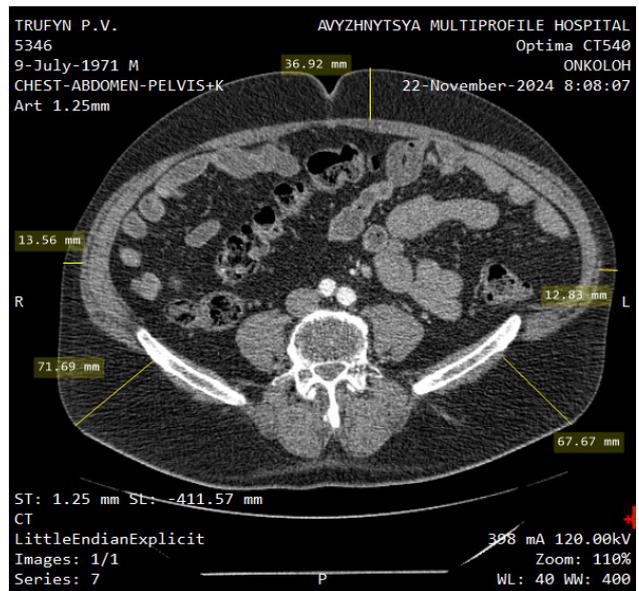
CT scan of patient T., 53 years old with grade I obesity, performed at the navel level. The thickness of the subcutaneous fat tissue ranges from 12.83 to 71.69 mm.
